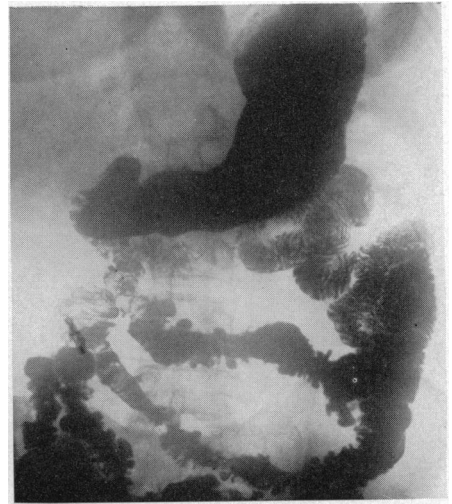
Roentgenogram of the same case as shown in Figure 3, three years later, after a gain of approximately 30 pounds. Note the partial restoration of the width of the intestinal lumen and mucosal pattern.
